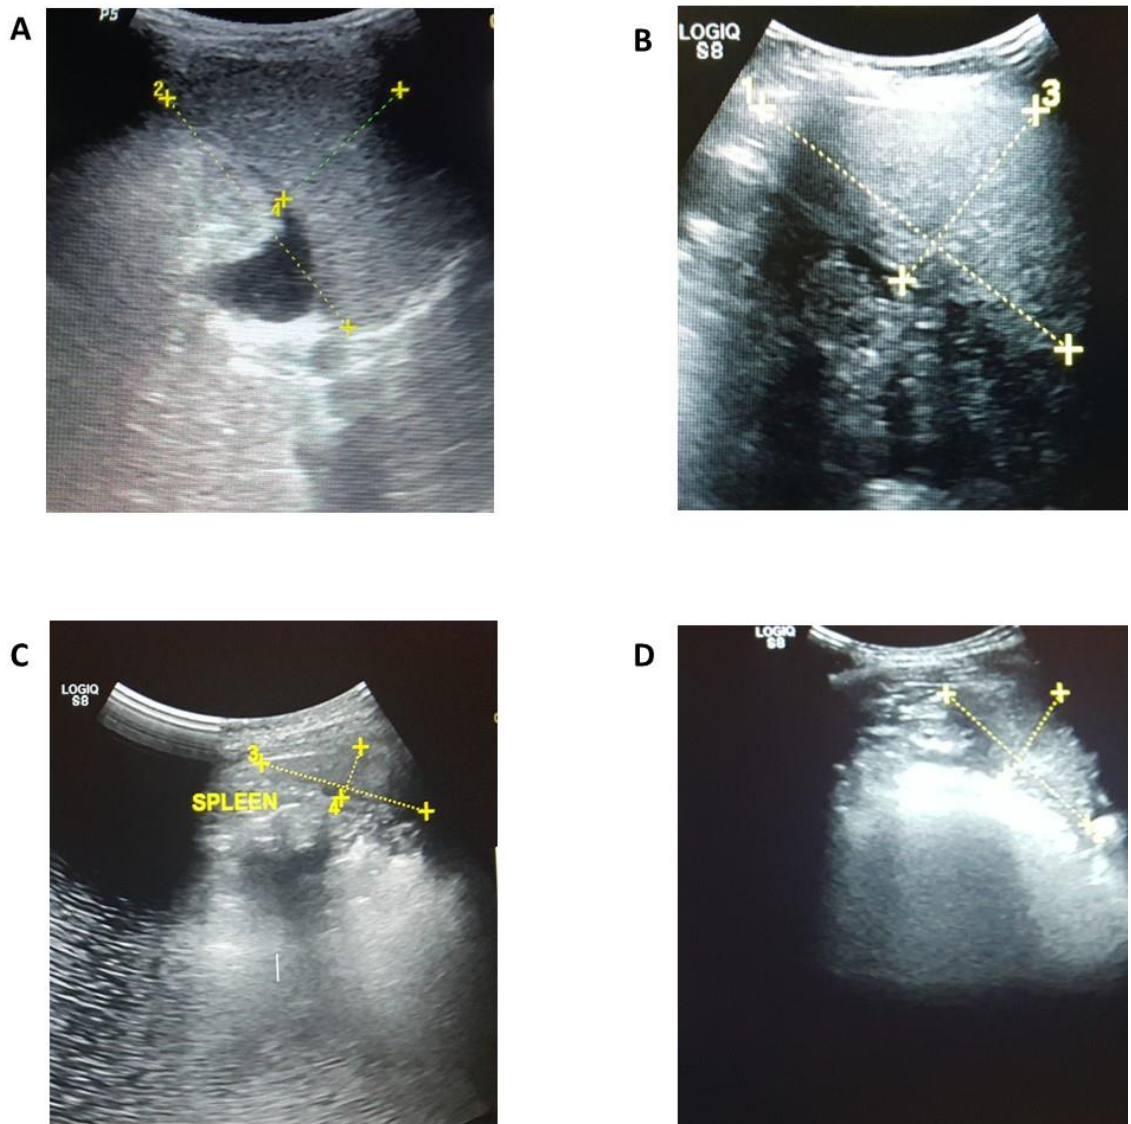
Abdominal ultrasonography showing normal and small-size spleens among SCD patients
